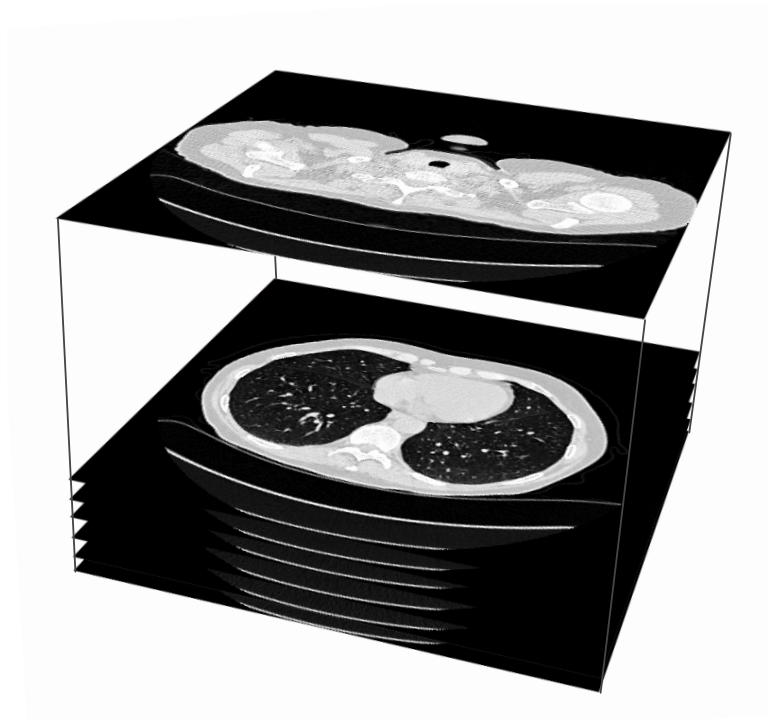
Three-dimensional CT image of the chest region created by stacking individual CT slices.
